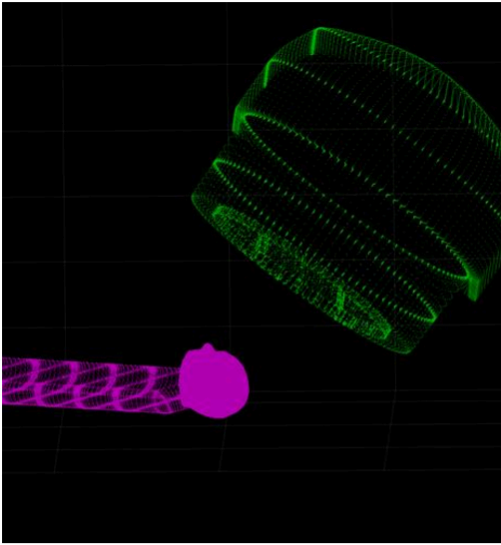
Patient CT and couch point cloud with the gantry head point cloud aligned.
